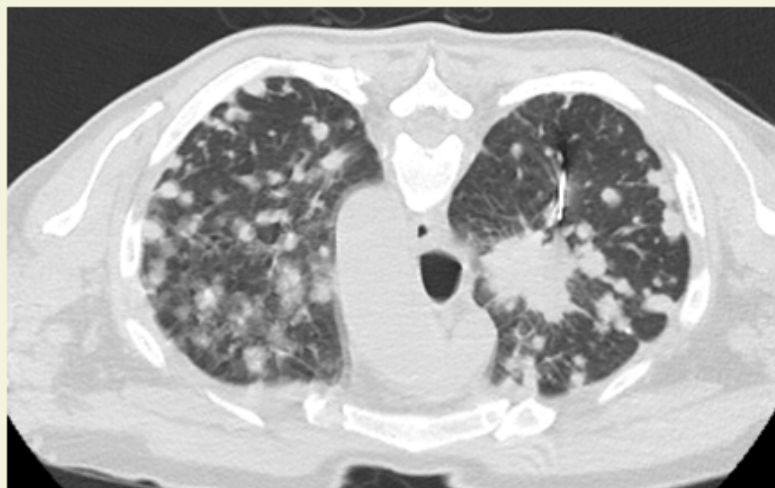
A axial section of CT chest in prone position shows multiple lung nodules and trucut biopsy needle approaching the lung mass on the right side.
